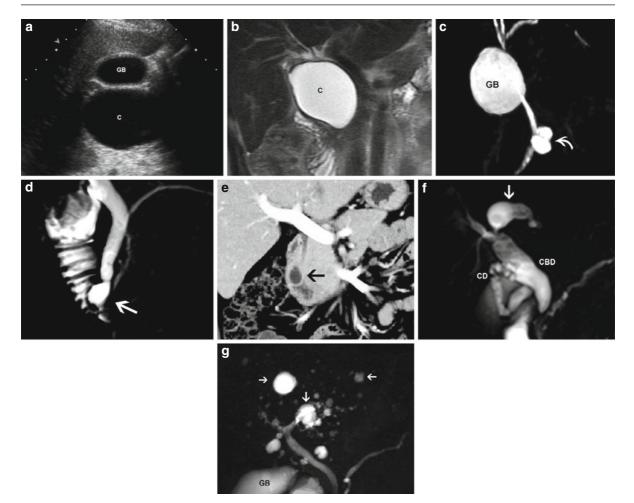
Choledochal cysts. (a) Type I. Ultrasound image of the right upper quadrant in transverse projection demonstrates an anechoic cystic structure (*C*) located inferior to the gallbladder (*GB*). (b) Type I. T2-weighted magnetic resonance image (MRI) in coronal projection demonstrates a simple fluid-filled cyst (*C*) in the right upper quadrant. (c) Type II. Coronal MRCP image shows diverticulum (*arrow*) of the common bile duct. (*GB* gallbladder). (d) Type III (choledochocele). Coronal MRCP image shows saccular dilatation (*arrow*) at the intraduodenal
